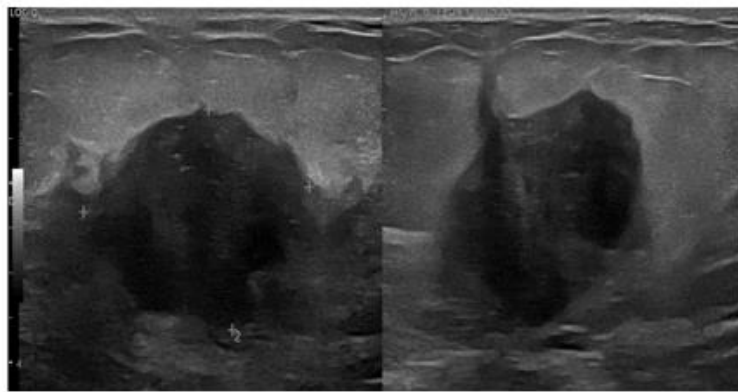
Ultrasound image showing a mass at the level of the upper outer quadrant of the left breast, oval in shape with regular contours, hypoechoic, heterogeneous classified as BI-RADS 4a lesion by ACR
